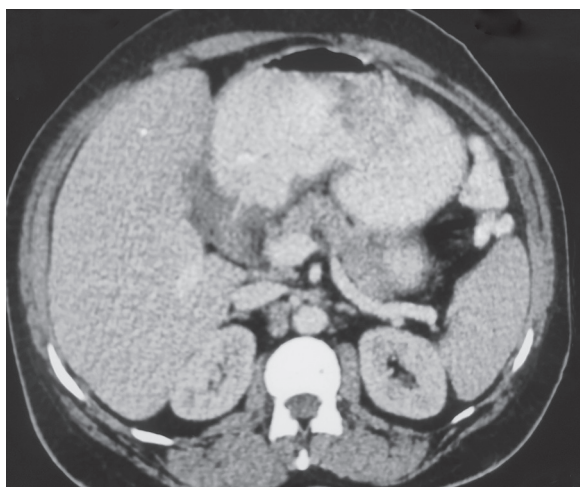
CT scan pyloric stenosis
